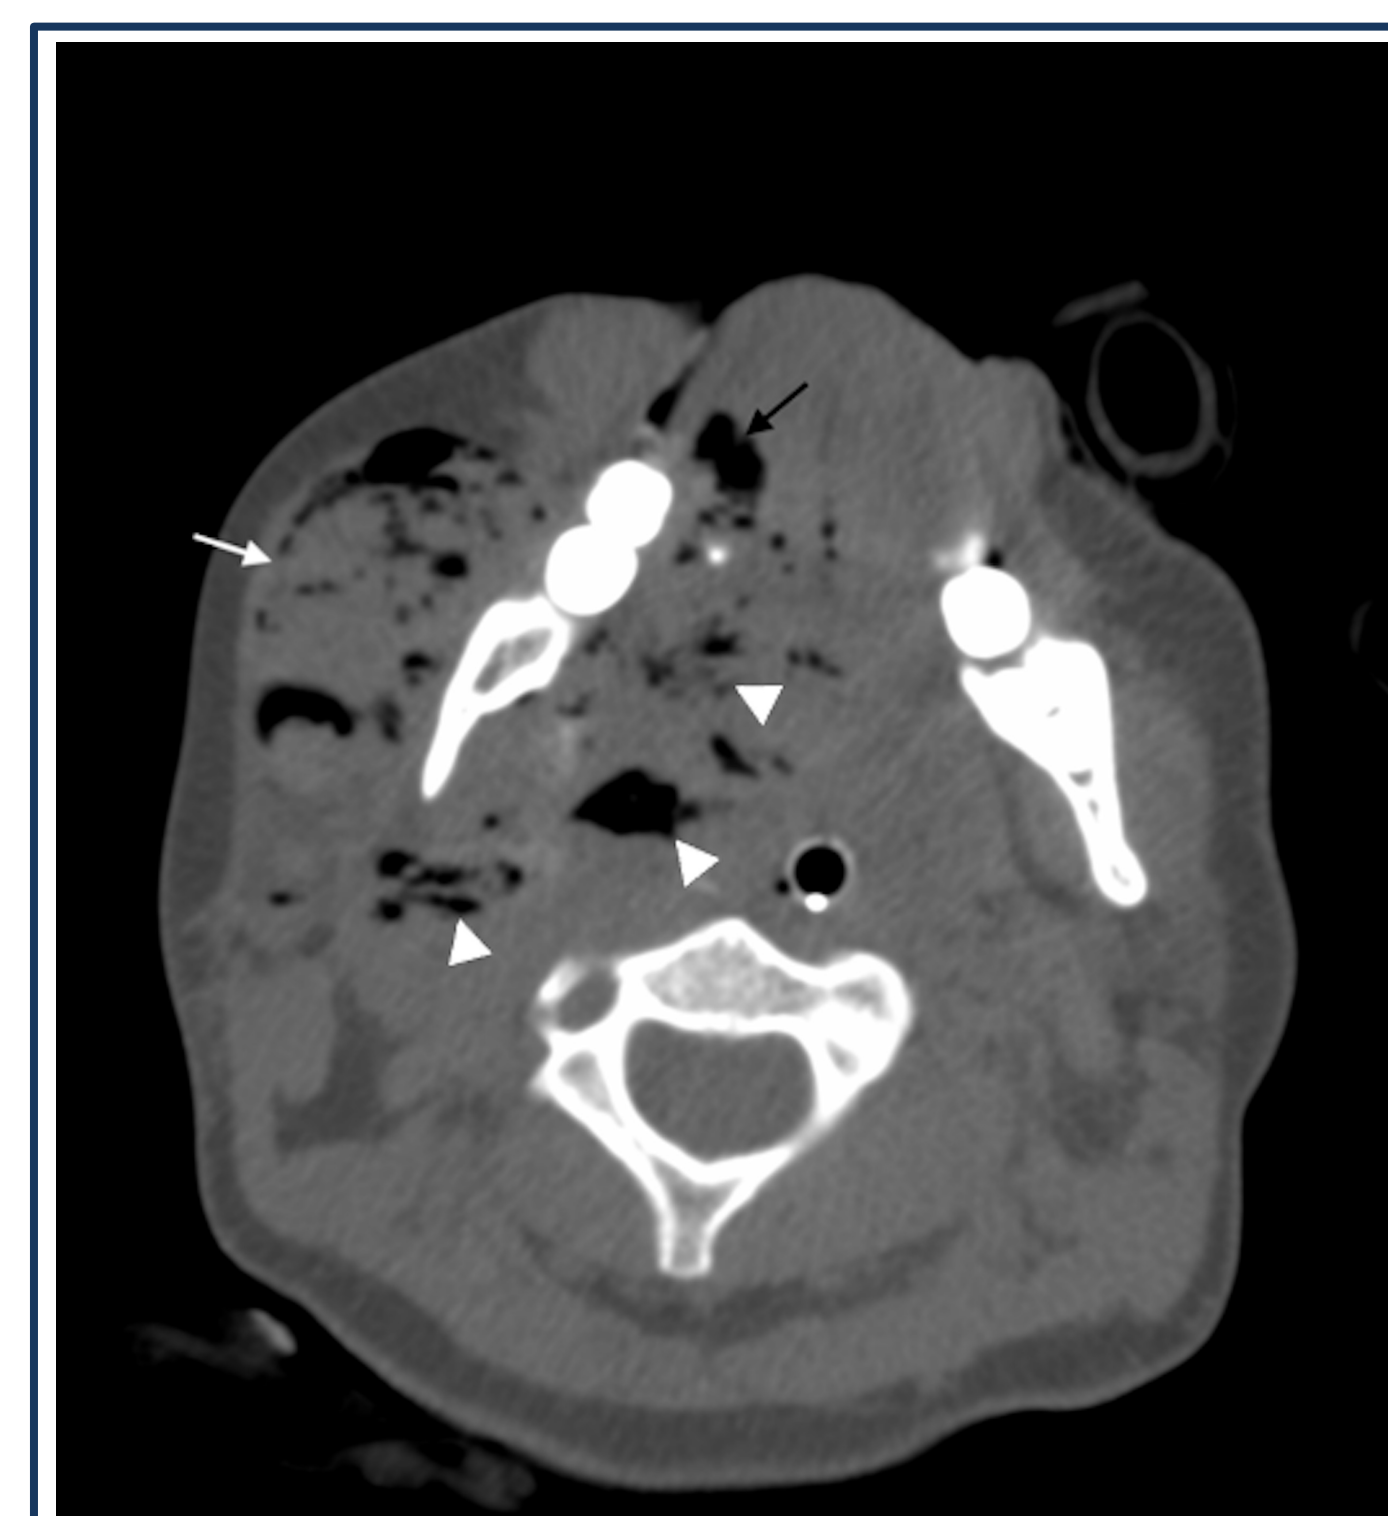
Post-sclerotherapy intra-procedural non-contrast CT image in axial plane showing immediate treatment changes within the right masticator (white arrow), right parapharyngeal (arrowheads), and right posterior tongue (black arrow) components of the venous malformation. An intra-tracheal tube was inserted for temporary airway protection against post-sclerotherapy oedema.
